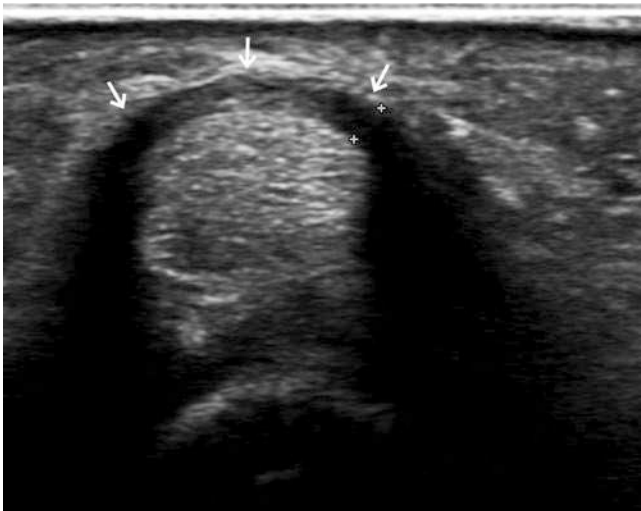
Transverse ultrasound of the middle finger metatarsophalangeal region in a patient with clinically apparent trigger finger. The A1 pulley (arrows) is markedly thickened (1.2 mm) as shown by the electronic calipers at the 2 o'clock position. Normal thickness of the A1 pulley is <0.5 mm. This is consistent with trigger finger
